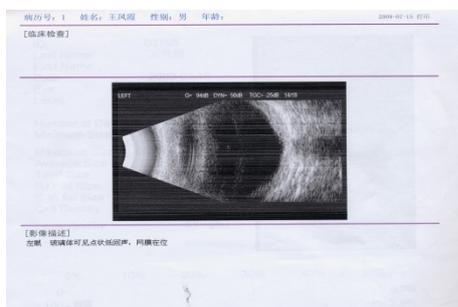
Ocular ultrasonography verified that the retina is in position.
